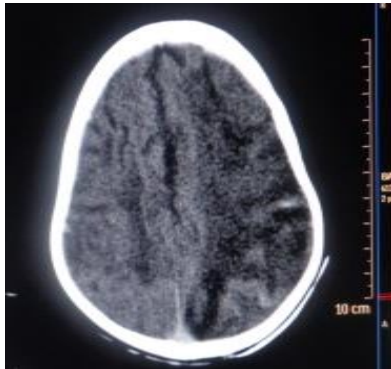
Axial non-contrasted brain CT scan showing an ill-defined hypodense lesion in the left parietal lobe.
